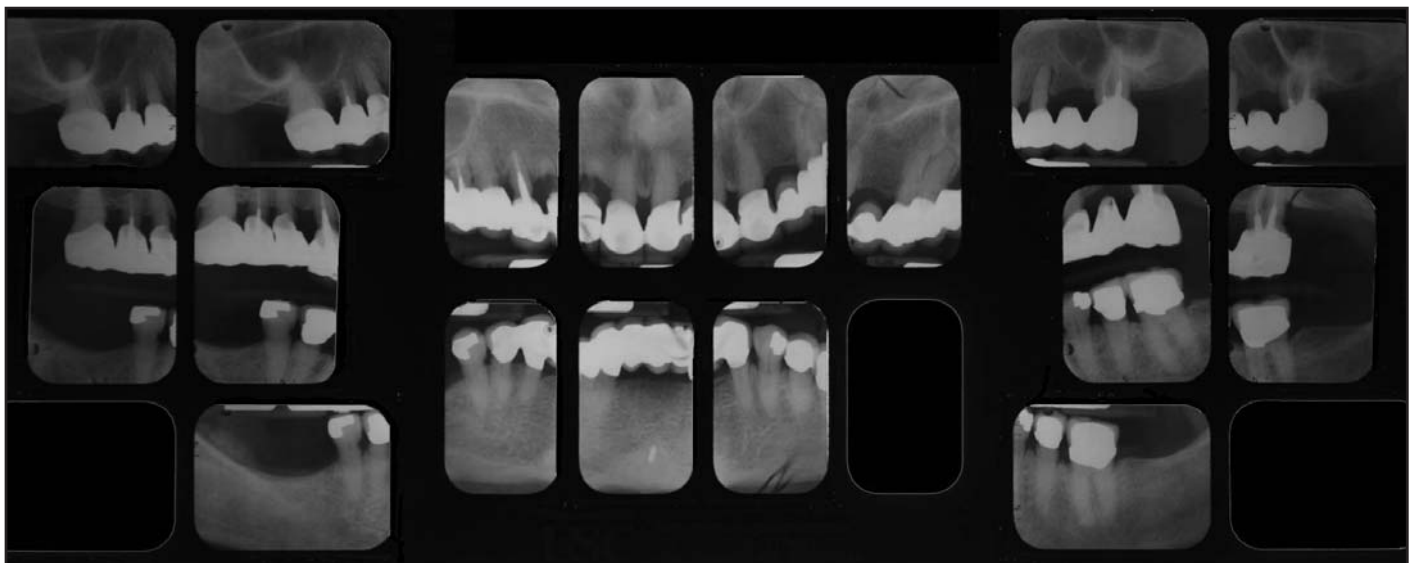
Full-mouth radiographs reveal caries on teeth Nos. 7 and 12, and very small roots.
